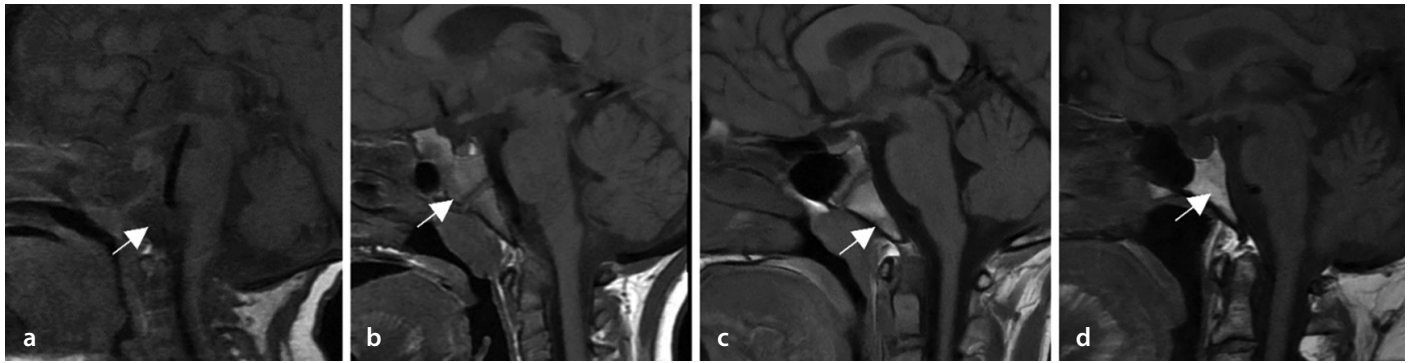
Signal changes in clival bone marrow on non-fat-suppressed T1-weighted (T1W) magnetic resonance imaging. Sagittal T1W images (a-d) without fat suppression from patients at 6 months (a), 4 years (b), 14 years (c), and adulthood (d) are shown. The images demonstrate the gradual replacement of red bone marrow (hypointense) by fatty bone marrow. The signal intensity changes are graded as grade 1 (a), grade 2 (b), and grade 3 (c, d), as indicated by the arrows.
